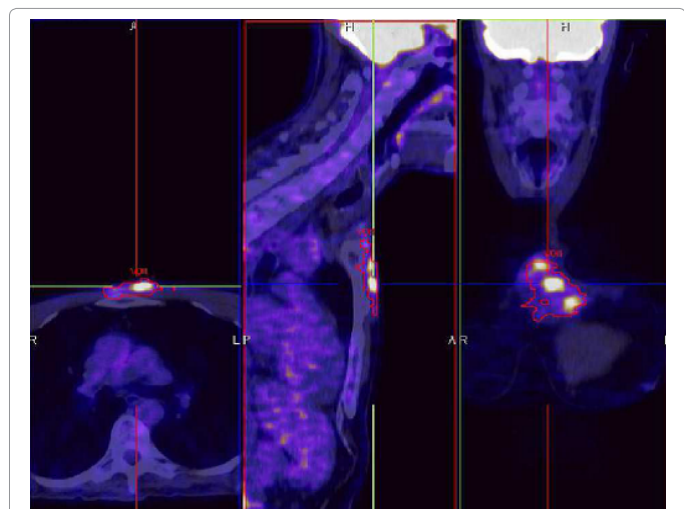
PET showing increased uptake of 18F-fluorodeoxyglucose in three rounded parasternal areas (Standardized uptake value equal to 6.45).
